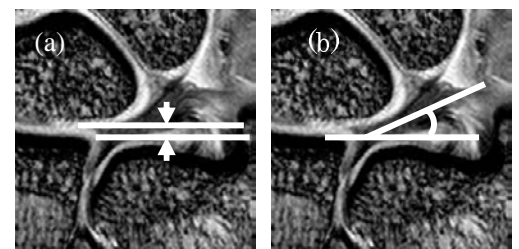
(a) Ulnar variance and (b) TFCC angle measured on MRI
